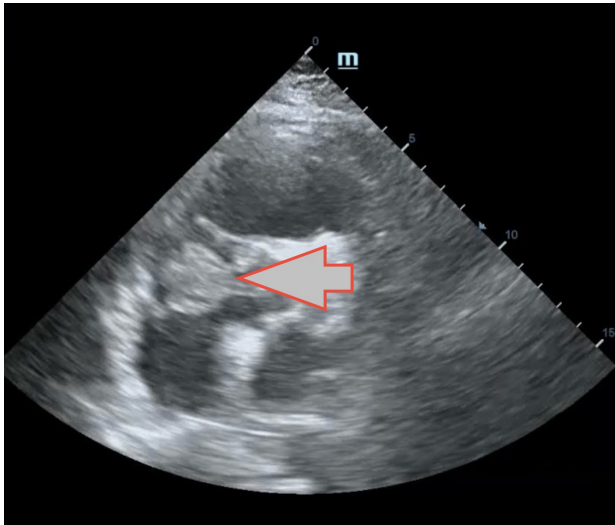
Echocardiogram showing right atrial mass consistent with myxoma
